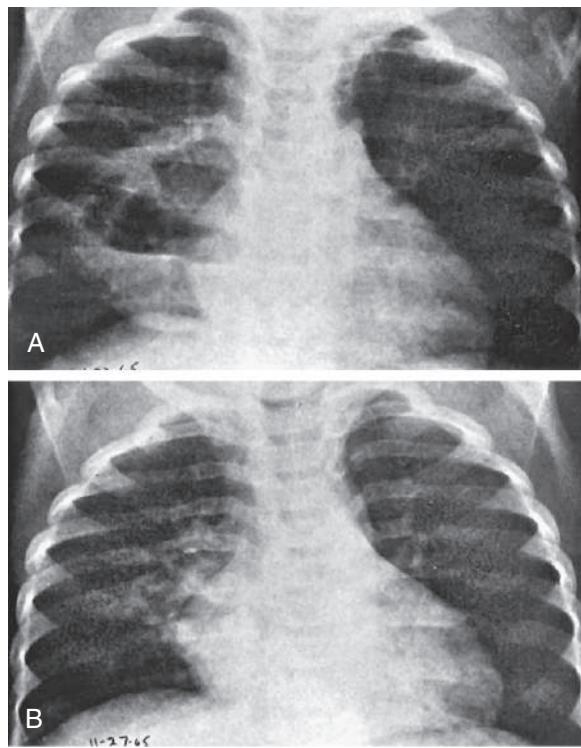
Appearance over a period of 5 days of a large, multiloculated pneumatocele in a segment of alveolar consolidation. A, There is a large cavity with two air-fluid levels in a segment of alveolar pneumonia in the right upper lobe. B, Five days later, the cavity and most of the pneumonic consolidation have disappeared. (From Silverman FN, Kuhn JP. *Essentials of Caffey's Pediatric X-ray Diagnosis*. Chicago: Year Book; 1990:303.)
